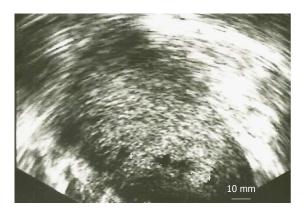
Ultrasound imaging of collapsed gestational sac after methotrexate treatment.
